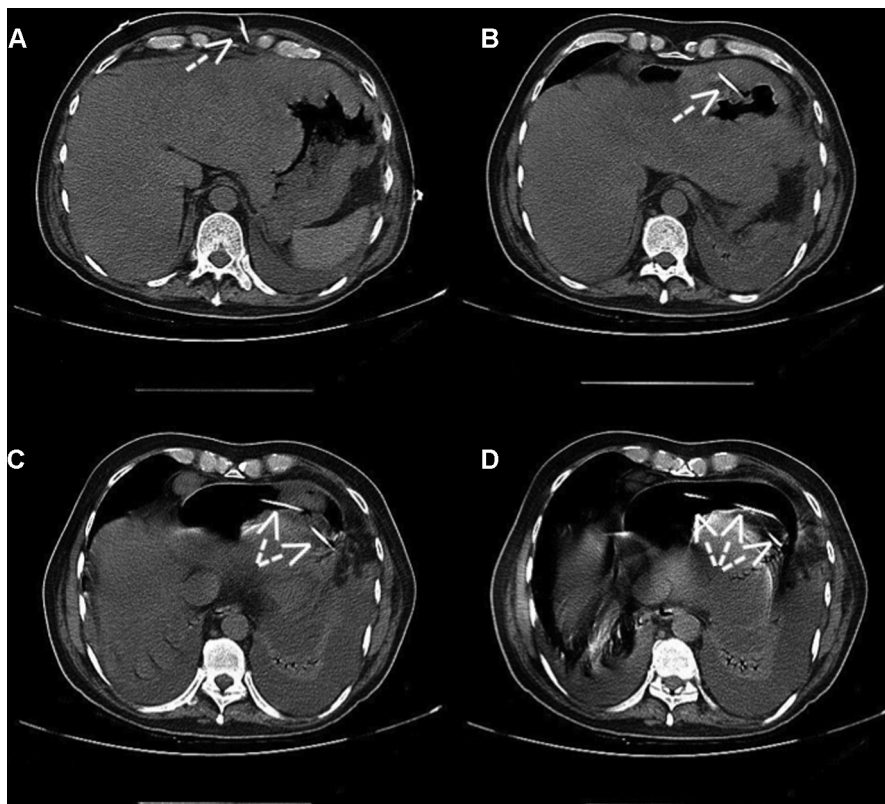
Computed tomography scan showing course of pericardial catheter (arrow) from skin (A) to pericardial space (D) traversing the stomach and the diaphragm (B and C).
